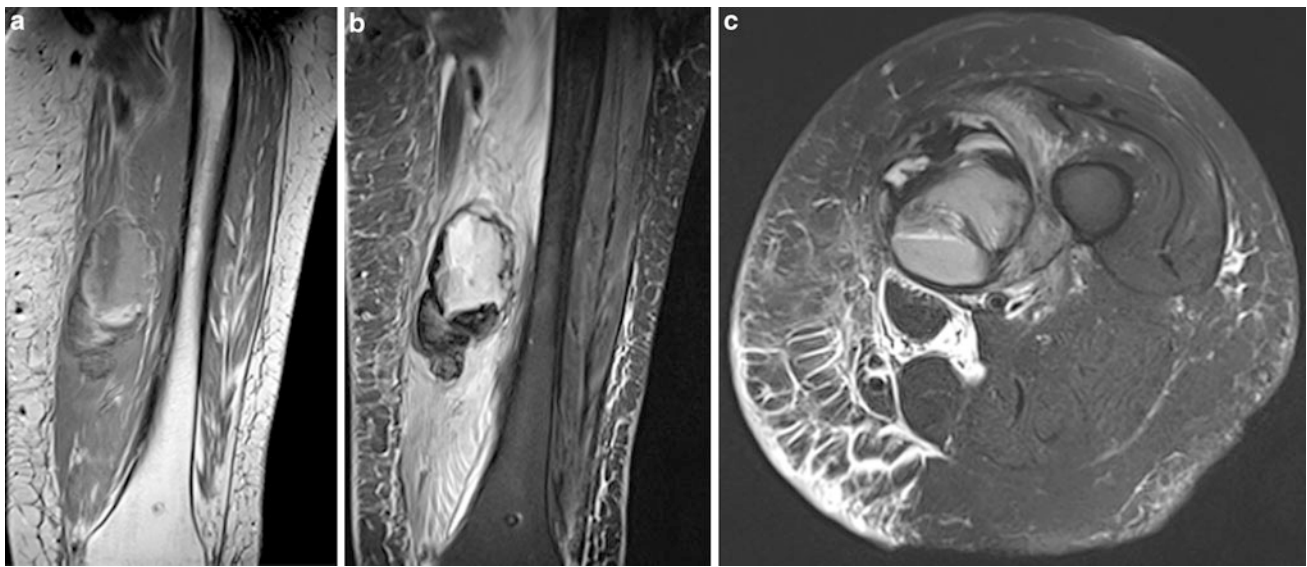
78-year old-woman under anticoagulatory therapy with phenprocoumon and presentation with sudden swelling and pain of left thigh. Coronal STIR sequence (a), coronal T1-weighted (b), and axial
